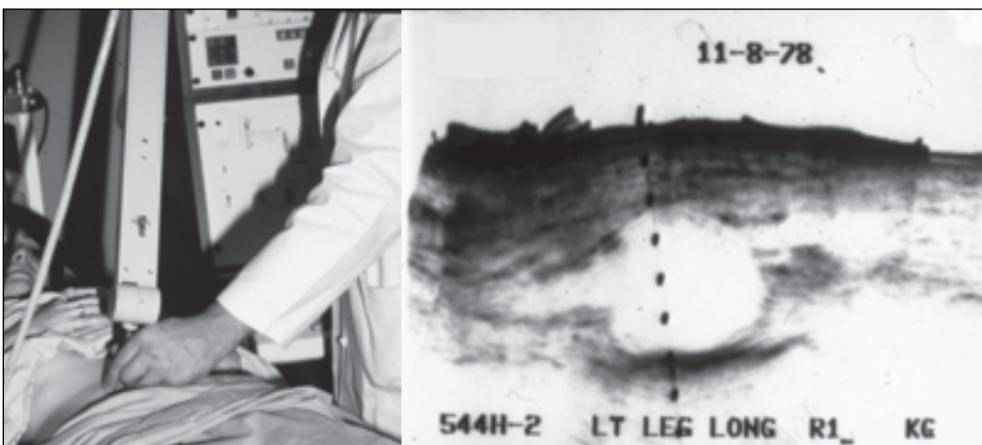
Ultrasound 1978. Articulated arm B-scanner and sagittal image of a large popliteal artery aneurysm. Images were created by manually moving the transducer in a series of arcs over the body until a complete 2-dimensional image was stored on the scan converter. Polaroid pictures of the screen made permanent records. The transducer was coupled to the skin with mineral oil. Some time later, and after much debate, white images on a black background were established as the standard.
